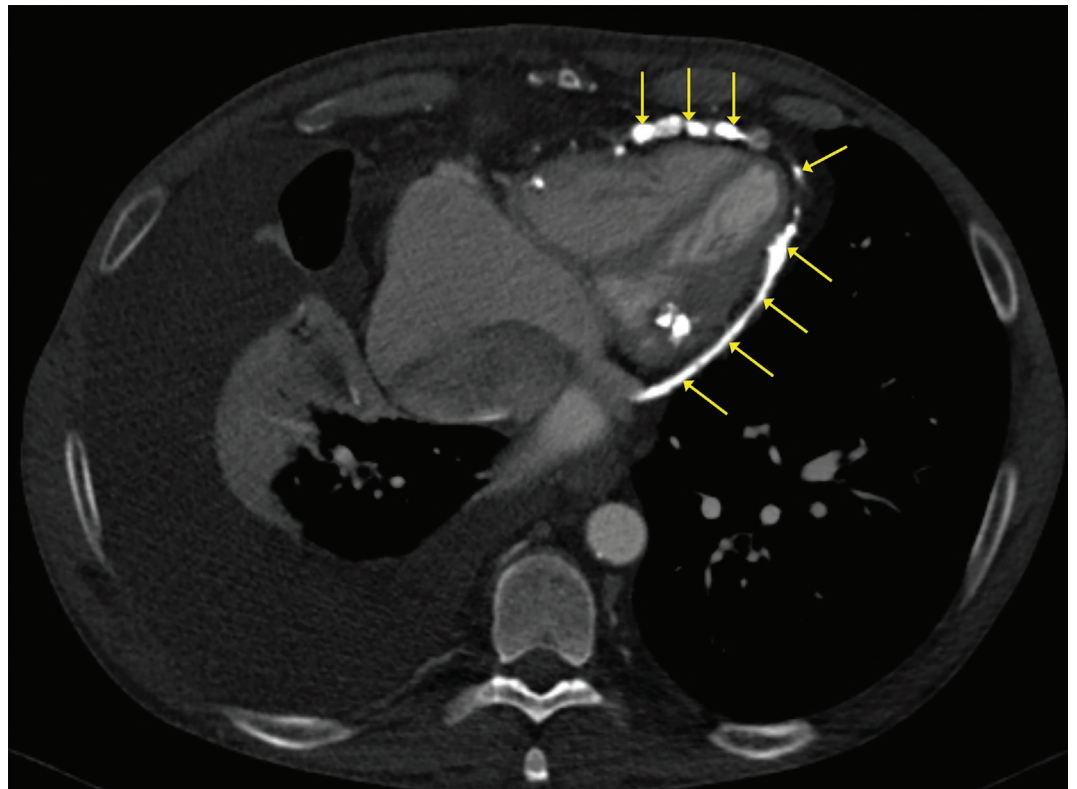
CT angiography of the heart in chronic constrictive pericarditis. Yellow arrows indicate a thickened and calcined pericardium.
